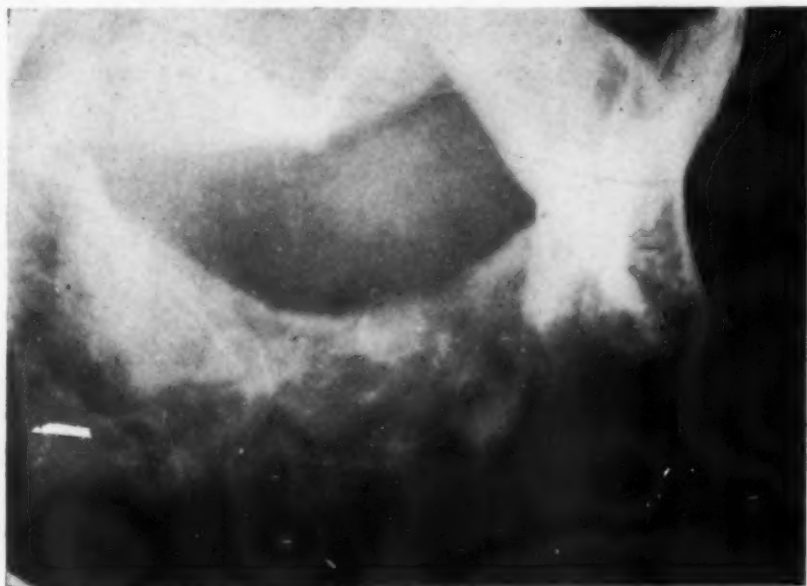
X-ray taken after removal of osteoma. Note osteoblastic formations in various parts of jaw.
